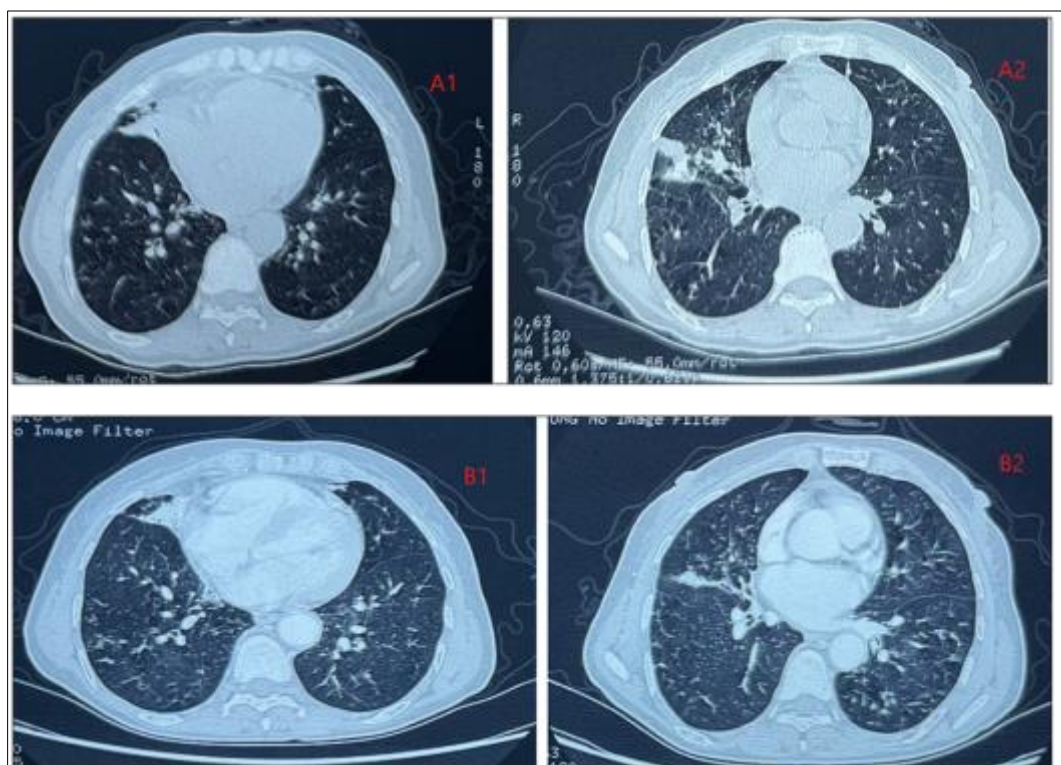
Images (A1 and A2) correspond to the initial investigations. A CT scan (B1 and B2) performed one year later revealed that the radiological lesions of bronchiolitis remained stable following therapeutic treatment
